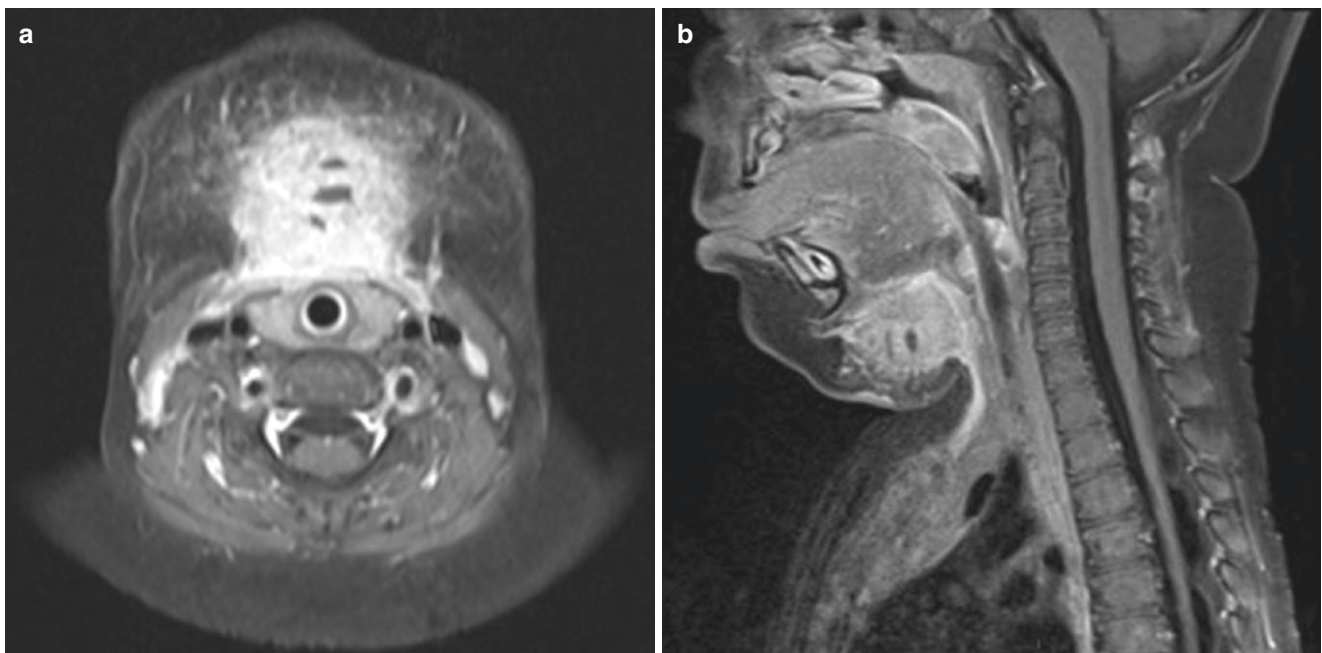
Infected thyroglossal duct cyst. Axial (a) and sagittal (b) post-contrast T1-weighted fat-saturated MR images demonstrate an enhancing mass in the sublingual region, containing small, central, non-enhancing fluid collections
